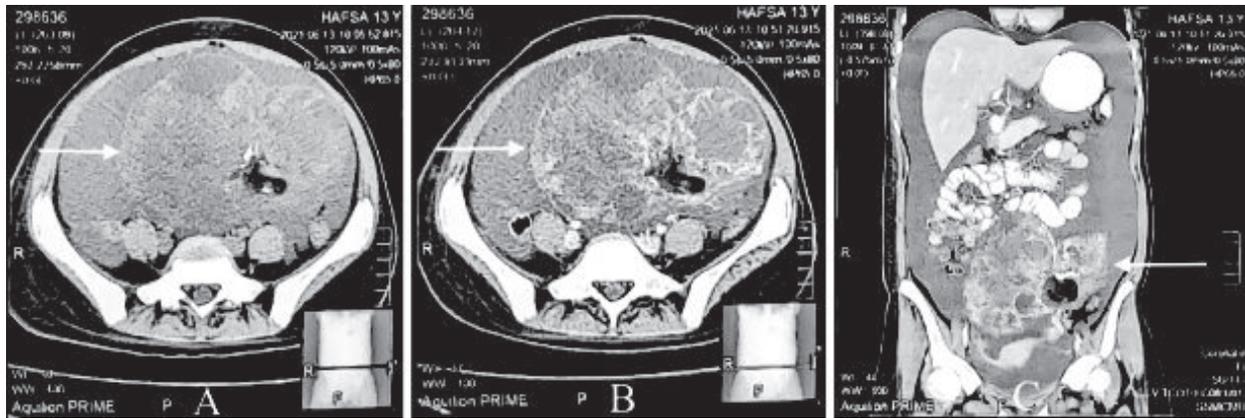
CT scan. A. Axial non-contrast image showing ascites and heterogeneous mass with solid & cystic components, fat-fluid densities and calcifications. B,C. Axial & reconstructed post-contrast images showing heterogeneous enhancement within the solid component.
